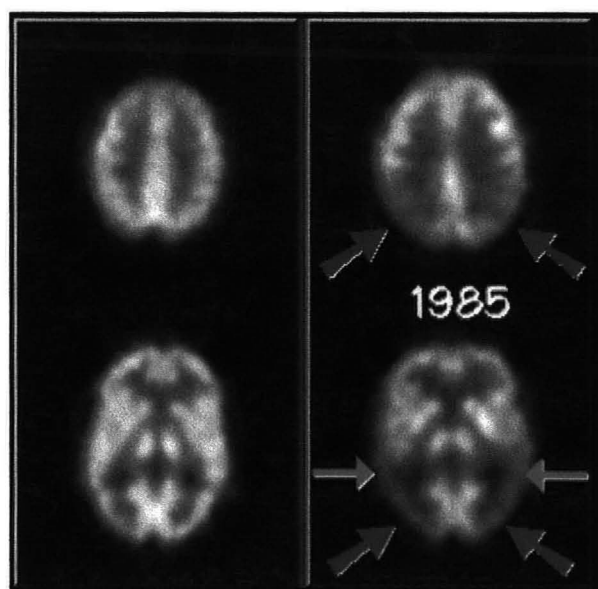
The left hand side is an FDG-PET scan from a normal volunteer, whilst the image on the right is from a patient diagnosed with Alzheimer's <sup>[56]</sup>.
